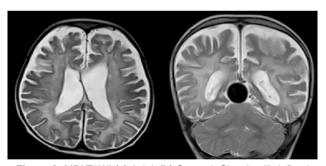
MRI T2WI (a) Axial, (b) Coronal- Showing ill-defined hyperintense areas in bilateral cerebral white matter and periventricular white matter and VGAM.
